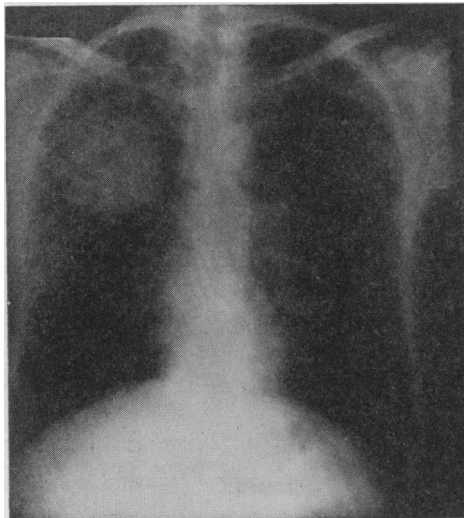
X-ray plate of chest, July 19, 1932, showing opacity in upper right lung field.
